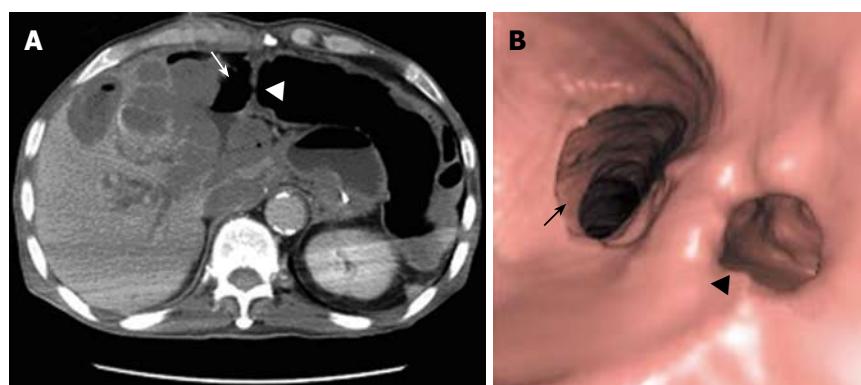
Diagnostic evaluation of perforating colon in present symptomatic patient during sunitinib treatment. A: In computed tomography, arrow and arrowhead show intraperitoneal free air and the site of colon perforation, respectively. B: In 3-dimensional reconstruction, arrow and arrowhead show the colon lumen and the site of perforation, respectively.
